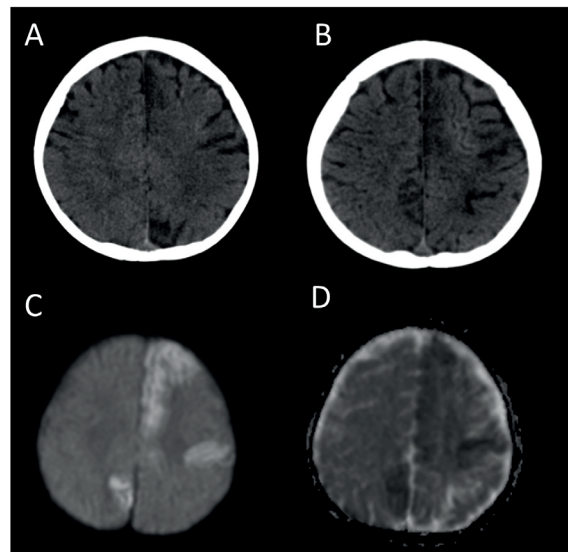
Images of an 18-month-old patient presenting with a right focal seizure lasting about 2 minutes. Axial non-enhanced CT images (A, B) show cortical hypodense lesions which then were shown as acute cortical infarcts by diffusion restriction of cytotoxic edema on diffusion-weighted imaging (C, D) obtained an hour later. The patient was diagnosed with hereditary spherocytosis on further work-up.
